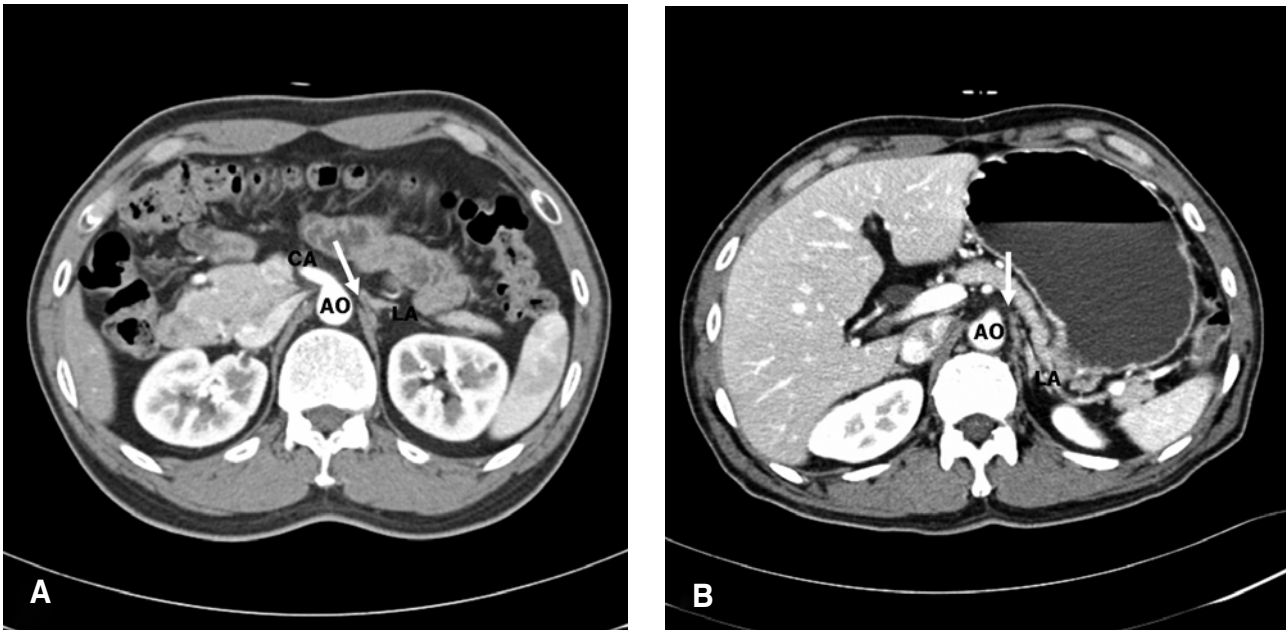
CT images demonstrating celiac ganglia (arrows) from two patients (A, B). AO, aorta; CA, celiac artery; LA, left adrenal gland.
